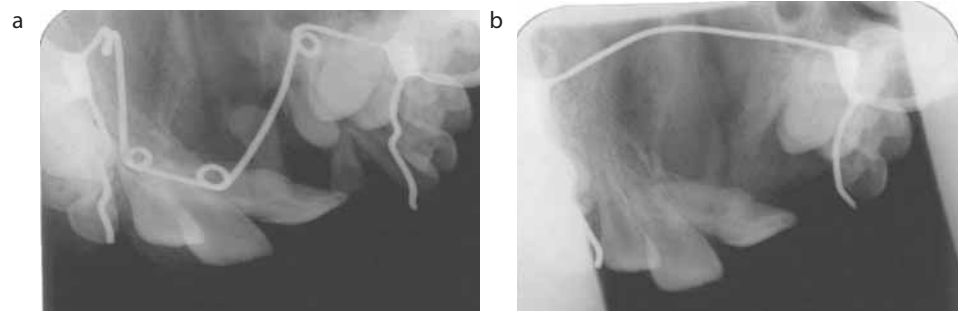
(a) Upper anterior radiograph for a patient with a unilateral cleft lip and palate showing two supernumeraries in the cleft site pre-bone graft. (b) Upper anterior radiograph for the same patient as (a) post bone graft operation showing good bony filling of the previous defect. The supernumerary teeth were also removed at operation.
